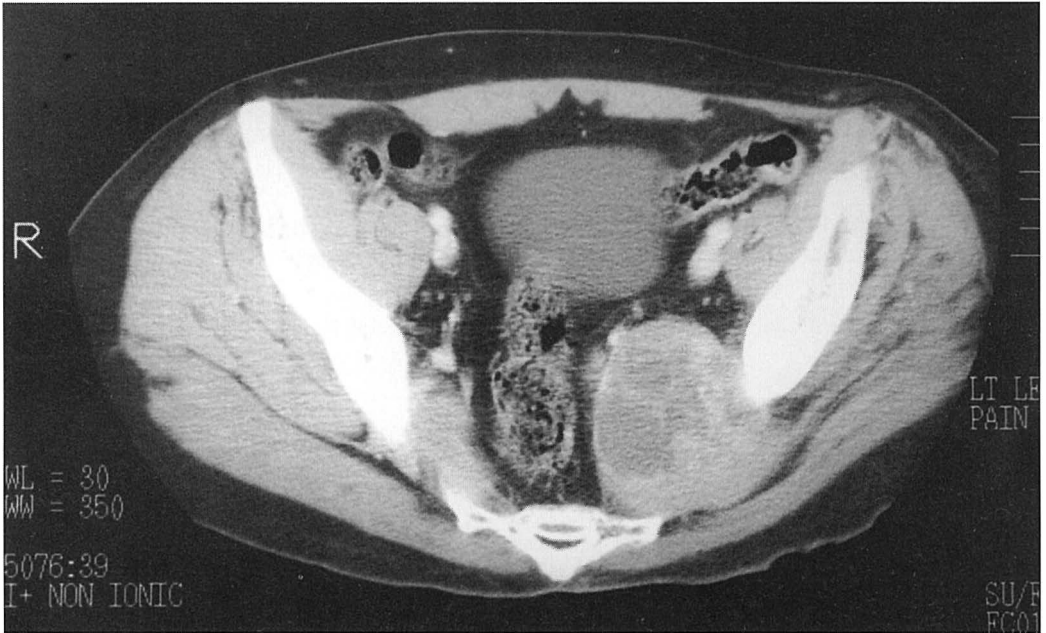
CT of the pelvis demonstrating a left pelvic mass. Tissue biopsy revealed a malignant peripheral nerve sheath tumor.
